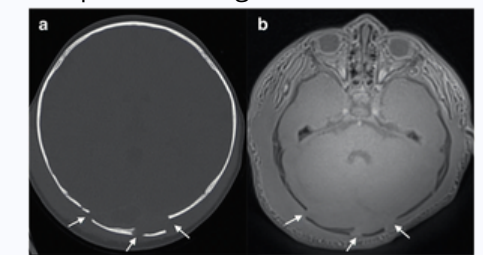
An 18-month-old female with multiple skull fracture (a) Head CT axial (b) axial black bone MRI
